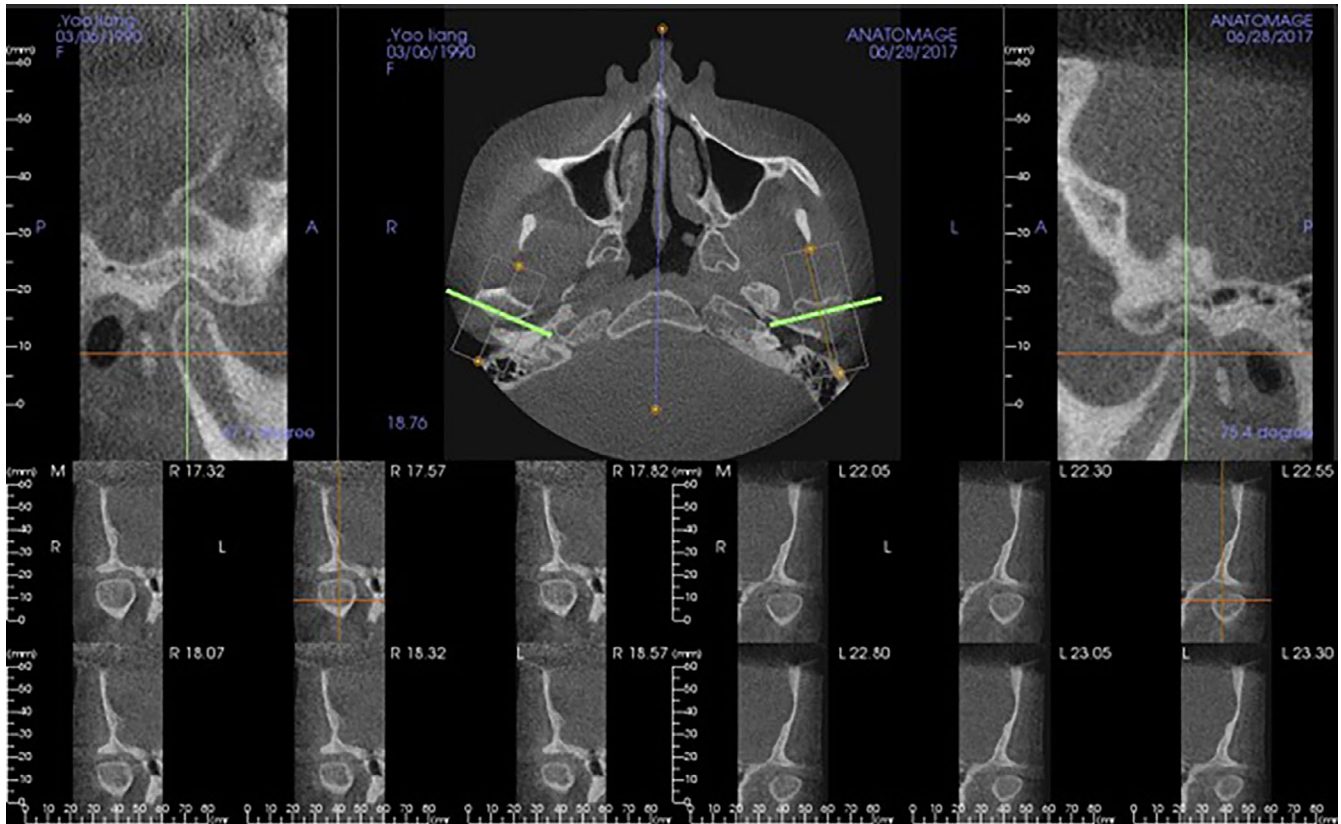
CBCT view of the TMJ images after occlusal reconstruction
